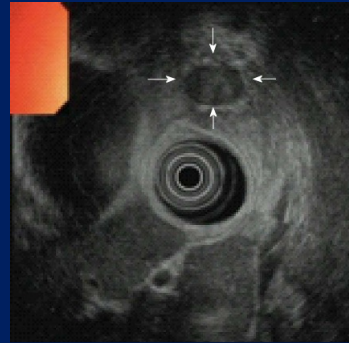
Endoscopic ultrasound featuring a homogeneously hypoechoic, rounded insulinoma.¹
